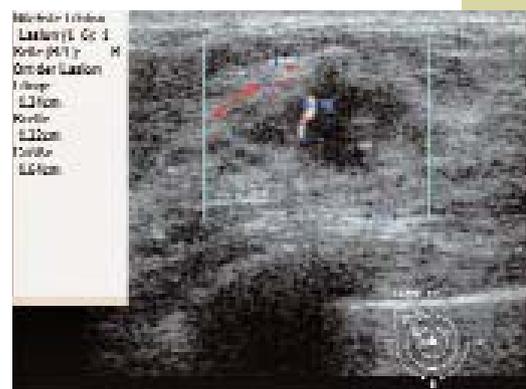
Finding from Fig. 18 in color Doppler: suspect, central vessel in the tumor
